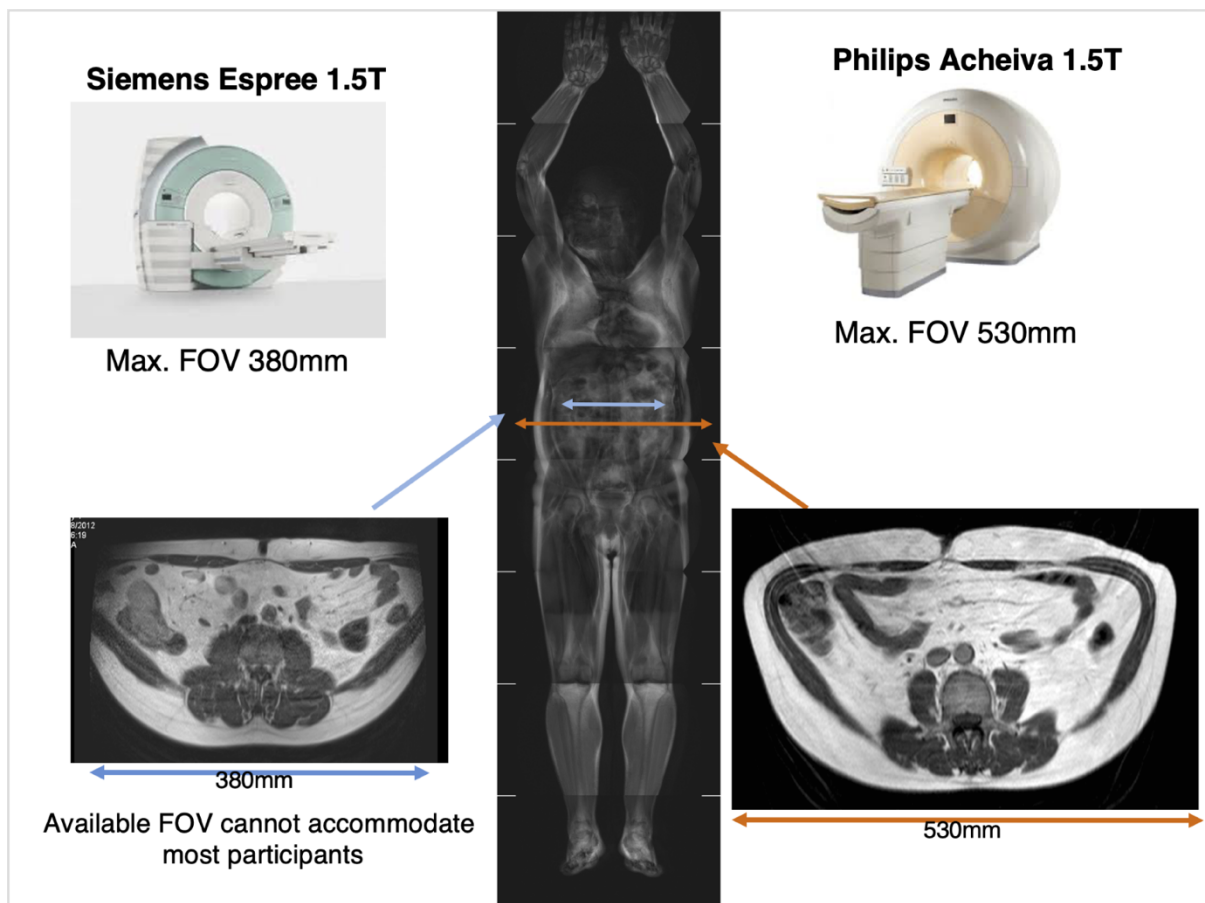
FOV in different MRI equipment
